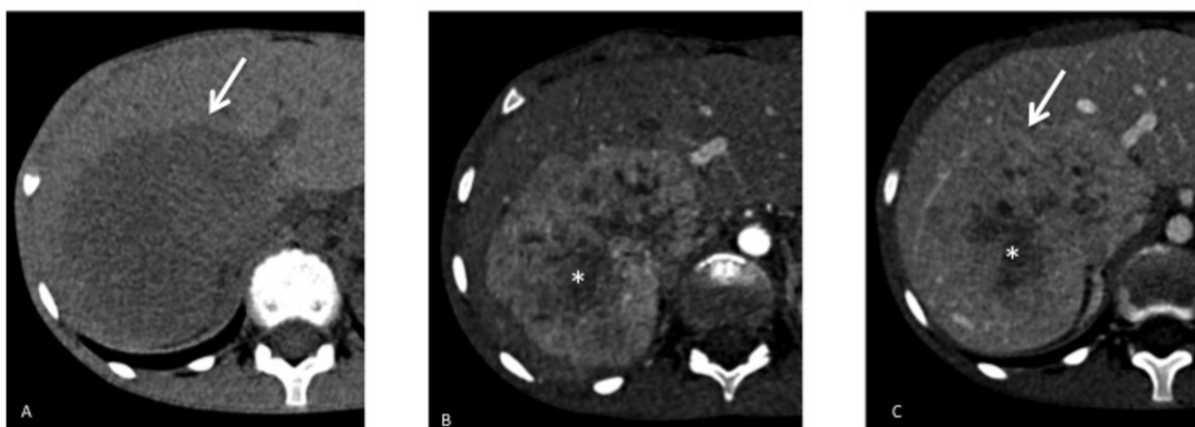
Fibrolamellar hepatocellular carcinoma (HCC). A - Axial unenhanced CT image shows large hypoattenuating mass (arrow) in right lobe. B - Axial CT image in arterial phase shows hypervascular enhancement within mass (arrow) and low-attenuation central scar (*) C - Axial CT image in portal venous phase shows mass is almost isoattenuating (arrow) compared with liver, and central scar (*) remains hypoattenuating.
